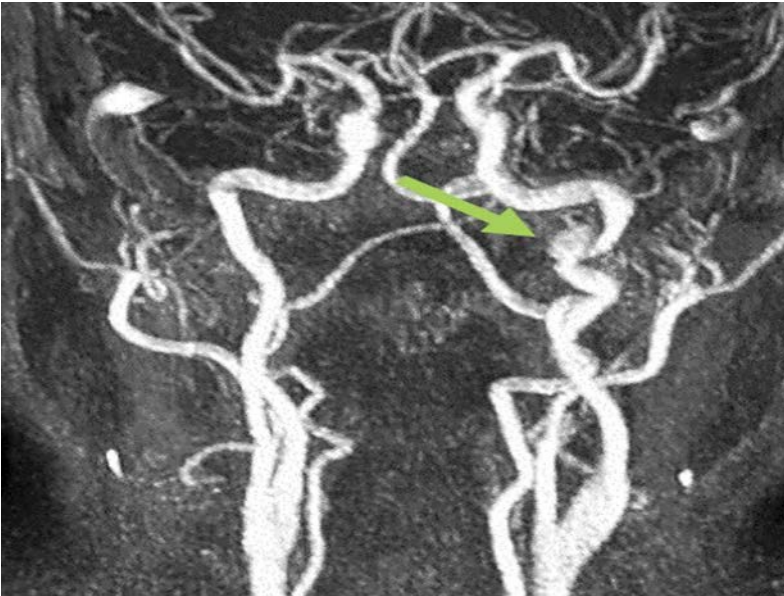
The CT angiography image demonstrates a well-defined saccular aneurysm arising from the internal carotid artery
